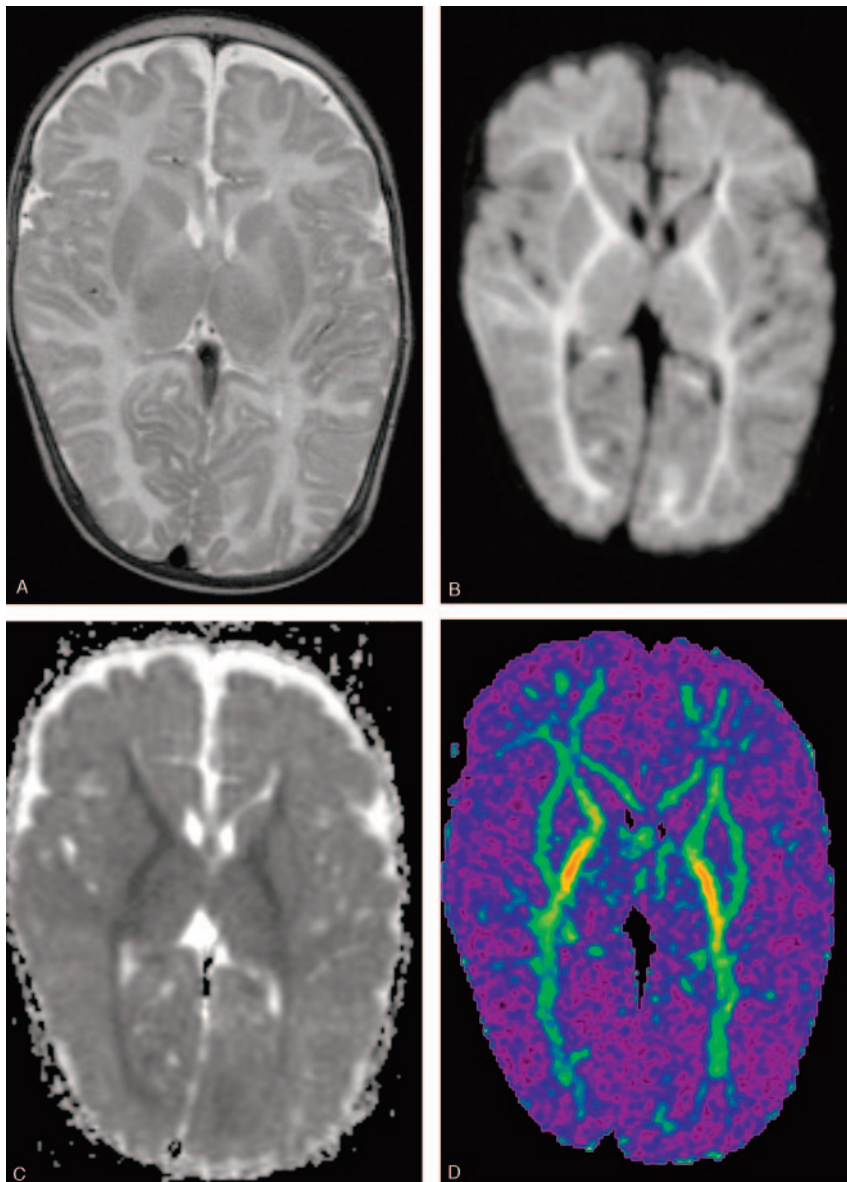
MR images at the age of 3 months.
